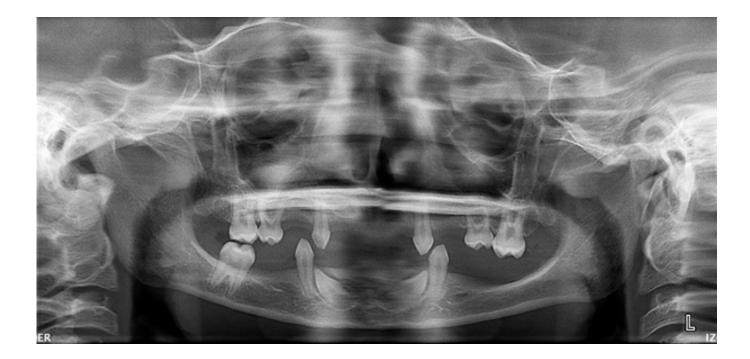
Orthopantogram (panoramic radiograph) of the patient's mother where the agenesia of the following teeth can be observed: upper lateral incisors (2), molars (2), lower central incisor (2).
